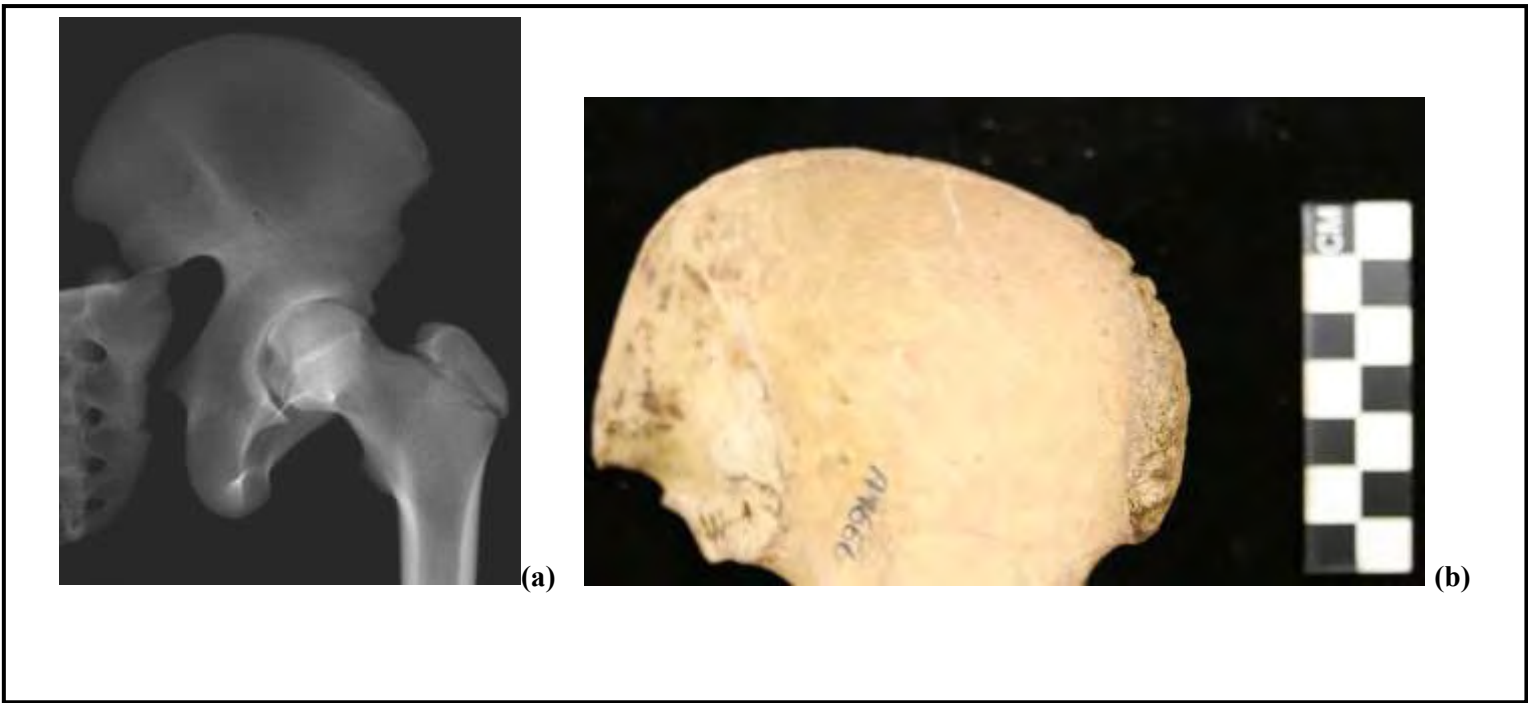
(i): Gross assessment at the skeletal hip and iliac crest. The radiograph (a) of the skeletal pelvis (b) showing an absence of the iliac crest, the iliac crest is open and hence scored as stage 1. The head of the femur in (a) is scored as 3 (showing greater than 50% union) and the greater trochanter as stage 2 while the absence of the lesser trochanter is scored as stage 1. The iliac crest in (b) is absent showing a ridge like formation suggesting the epiphysis is open.
